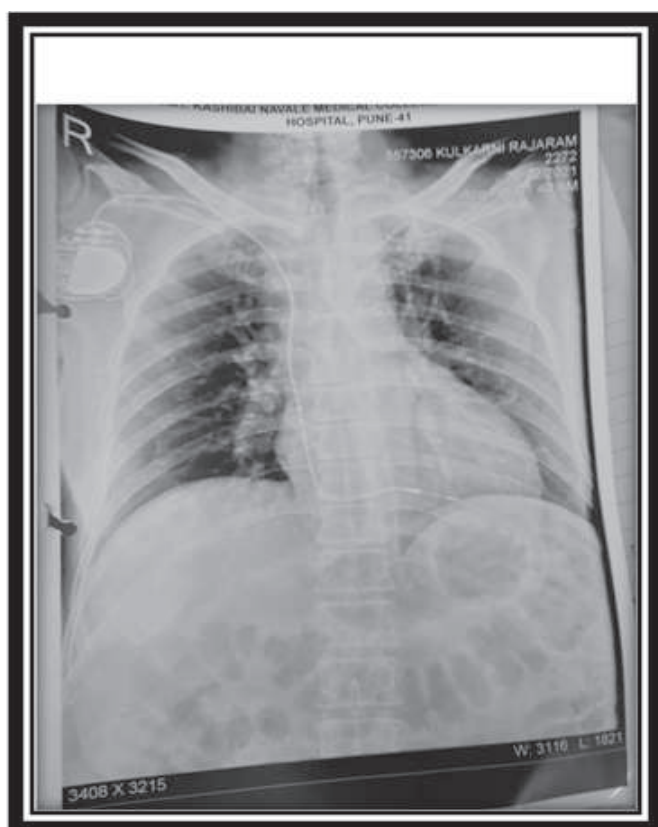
showing Chest X-ray Antero Posterior view of the patient with PPM device in situ situated at right axillary area with continuity of lead.
